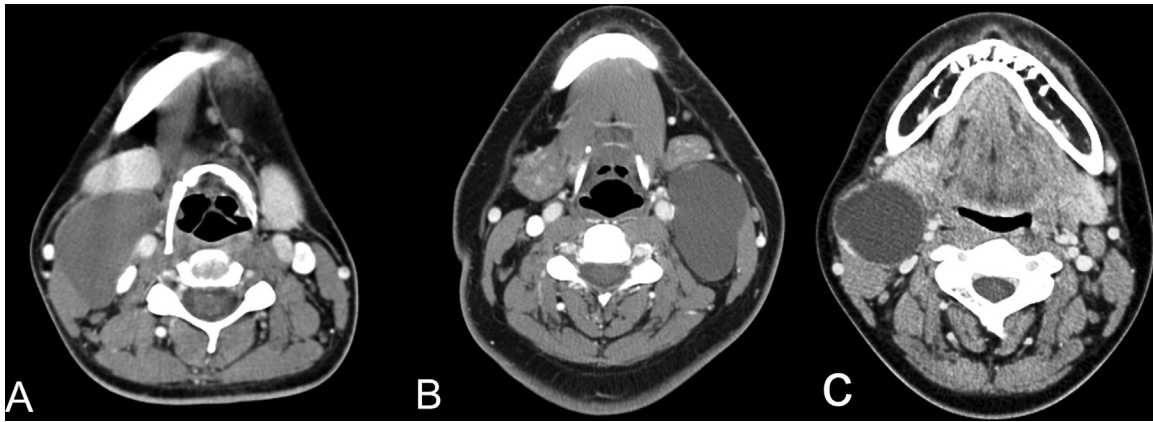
Preoperative neck imaging. (A) Axial computed tomography (Case 1) reveals a 5 cm unilocular cystic mass in the posterior-inferior aspect of the right submandibular gland. (B) Axial computed tomography (Case 2) reveals a 6 cm cystic mass with suspicious internal septation in the left level II of the medial aspect of the upper sternocleidomastoid muscle. (C) Axial computed tomography (Case 3) reveals a 4 cm unilocular cystic mass between the right submandibular gland and sternocleidomastoid muscle.
